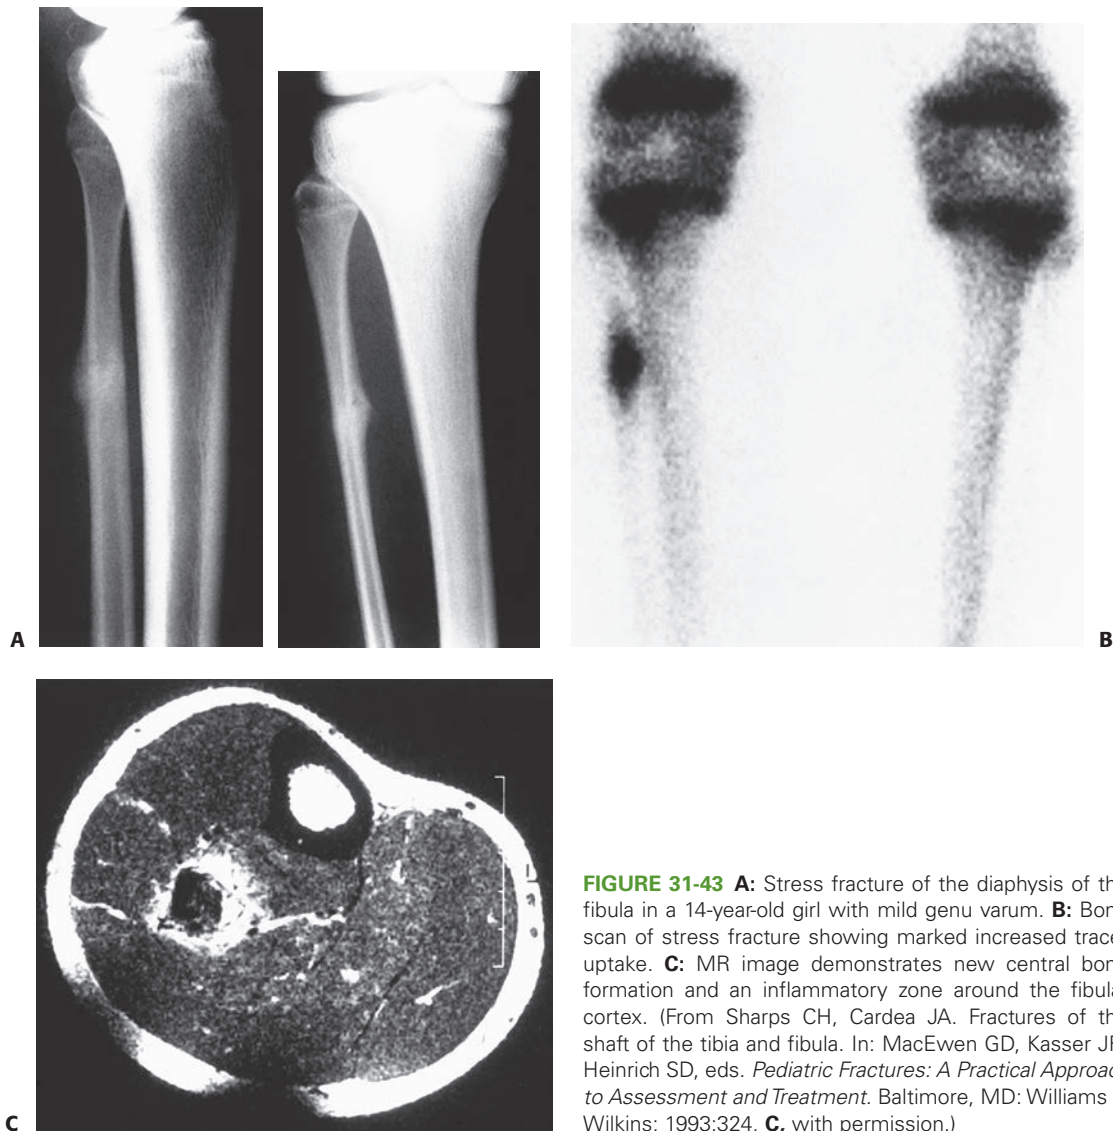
A: Stress fracture of the diaphysis of the fibula in a 14-year-old girl with mild genu varum. B: Bone scan of stress fracture showing marked increased tracer uptake. C: MR image demonstrates new central bone formation and an inflammatory zone around the fibular cortex. (From Sharps CH, Cardea JA. Fractures of the shaft of the tibia and fibula. In: MacEwen GD, Kasser JR, Heinrich SD, eds. *Pediatric Fractures: A Practical Approach to Assessment and Treatment*. Baltimore, MD: Williams & Wilkins; 1993:324, C, with permission.)
